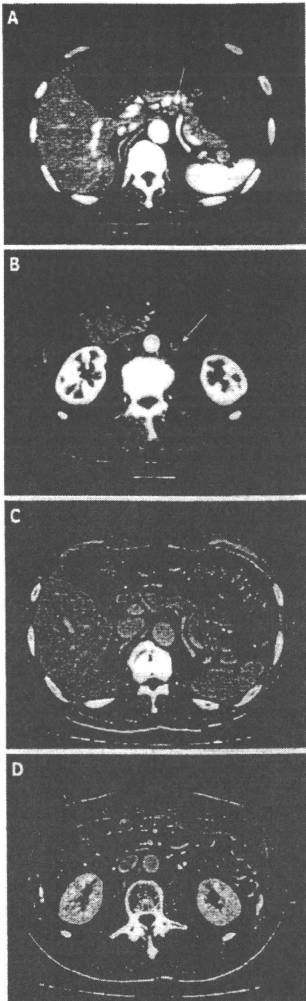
Abdominal CT scan findings. A: CT scan showing lymph node metastasis in the lymph nodes around the celiac artery (arrow); B: Abdominal CT showing lymph node metastasis in the paraortic region (arrow); C, D: After CRT, abdominal CT demonstrated a remarkable reduction of lymph node size.
